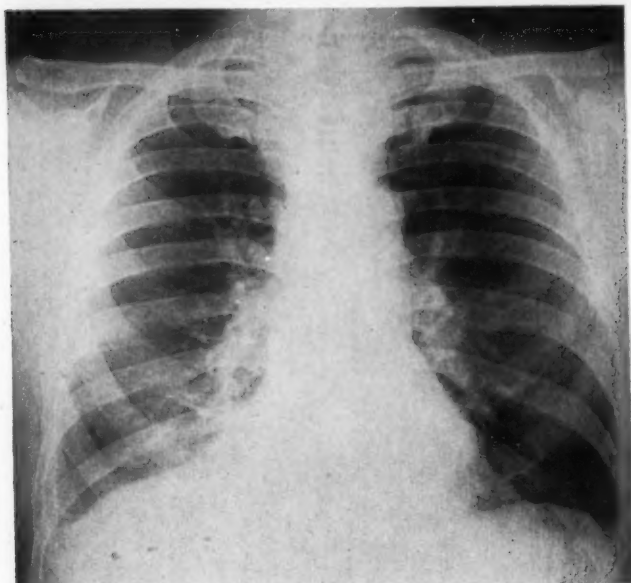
Chest X-ray taken May 25, 1946, showing clearing of lung fields.
